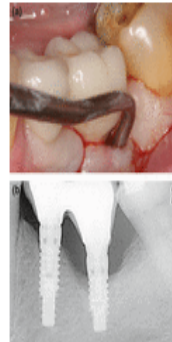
(a) Probing of an implant with peri-implantitis; (b) Radiographic evidence of progressive bone loss.
